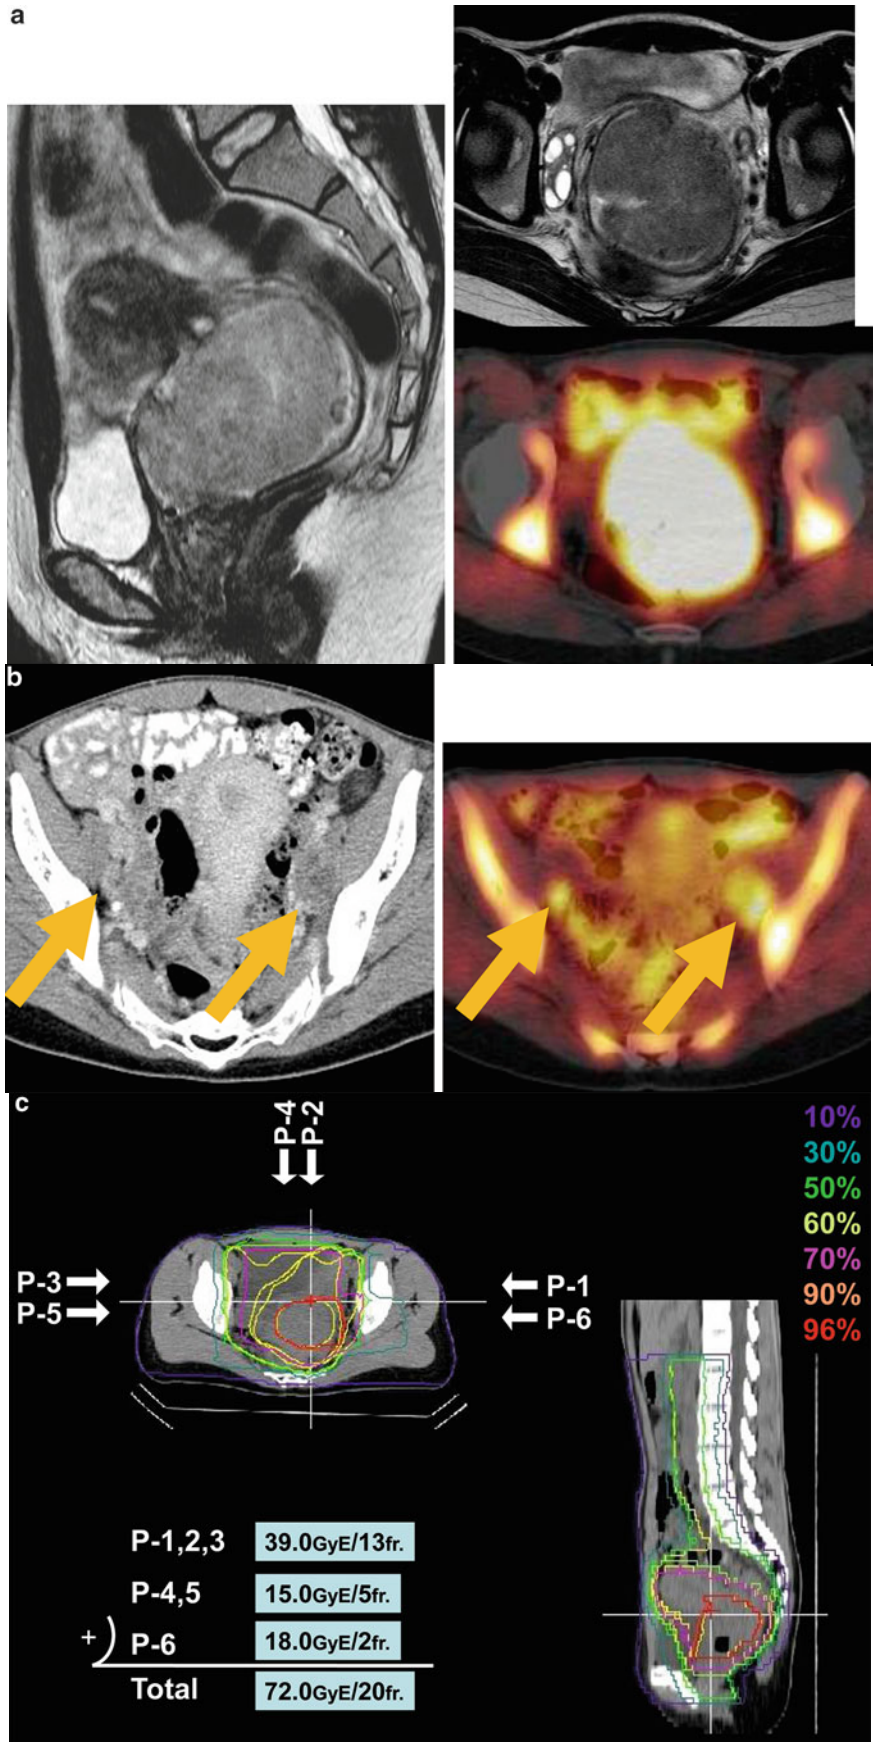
(a) MRI and the methionine-PET scan images of uterine cervix before treatment. (b) CT and the methionine-PET scan images of pelvic lymph node before treatment. (c) Dose distribution of C-ion RT. (d) MRI images 6 months after C-ion RT
